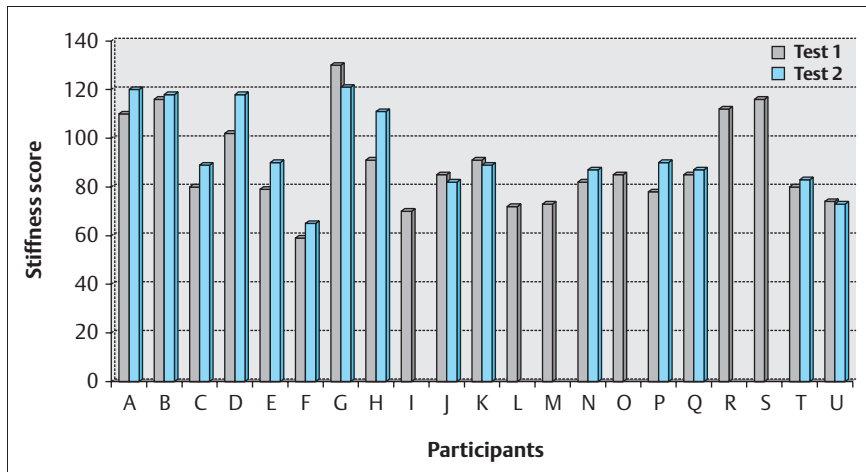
Bone ultrasound results.
